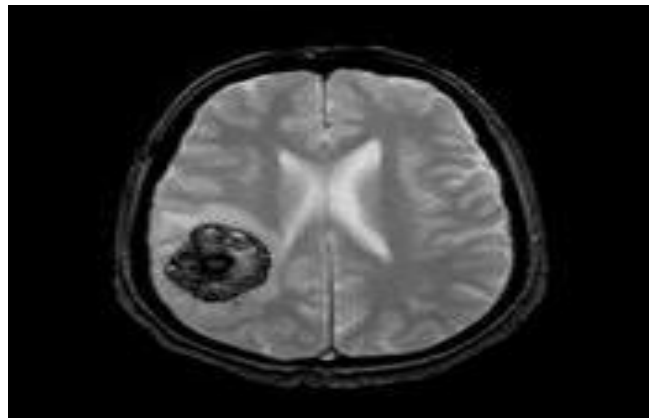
MRI brain axial section T1 waited image with contrast(Ronald L.Eisenberg Nancy M. Johnson ,Comprehensive Radiographic Pathology)
